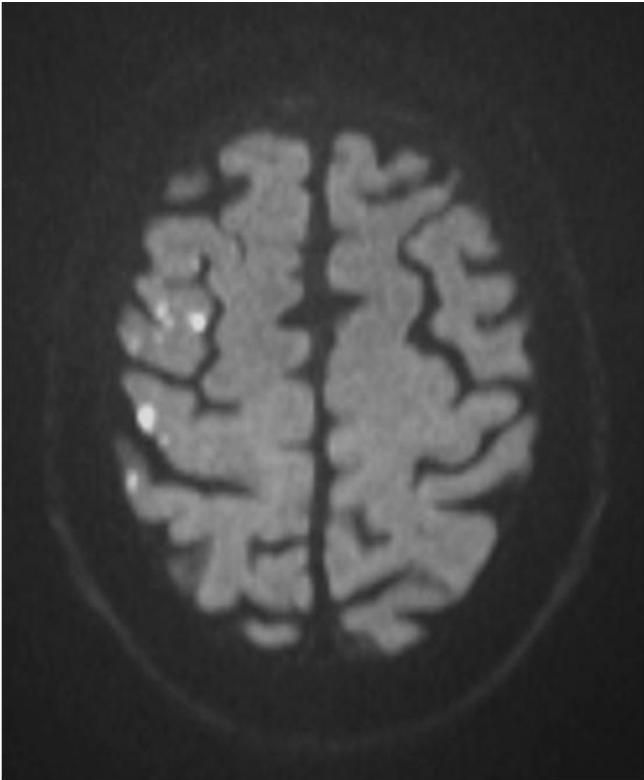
Diffusion weighted magnetic resonance imaging (DWI) of a patient following stenting of the right carotid artery.
